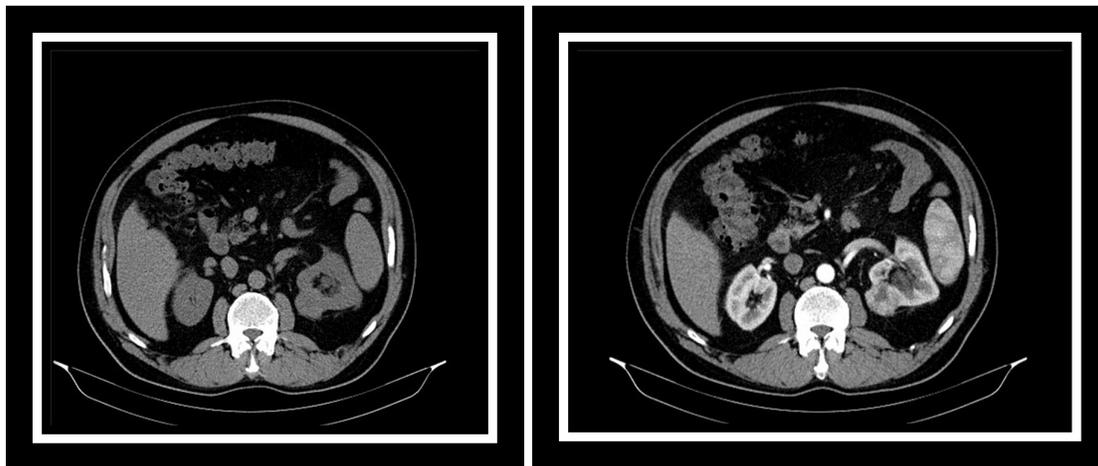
Cross sectional computed tomography image showing the mass on the left kidney
